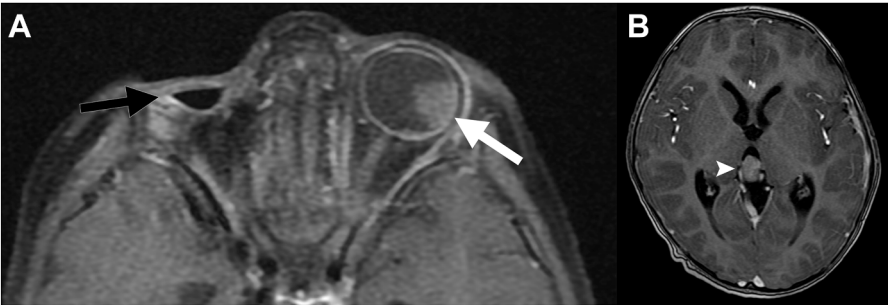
Axial fat-suppressed gadolinium-enhanced T1-weighted MR sequences of the orbit (A) and brain (B) demonstrating trilateral retinoblastoma: an enhancing left globe tumor (white arrow), right enucleation due to retinoblastoma (black arrow) and an enhancing pineal mass (white arrowhead).
